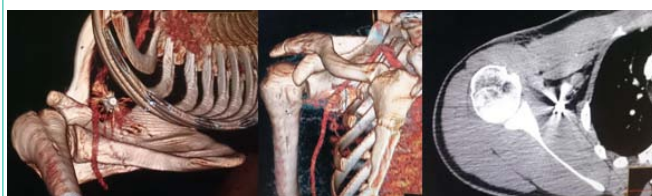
CT scan of the right shoulder showing the location of the foreign body.
